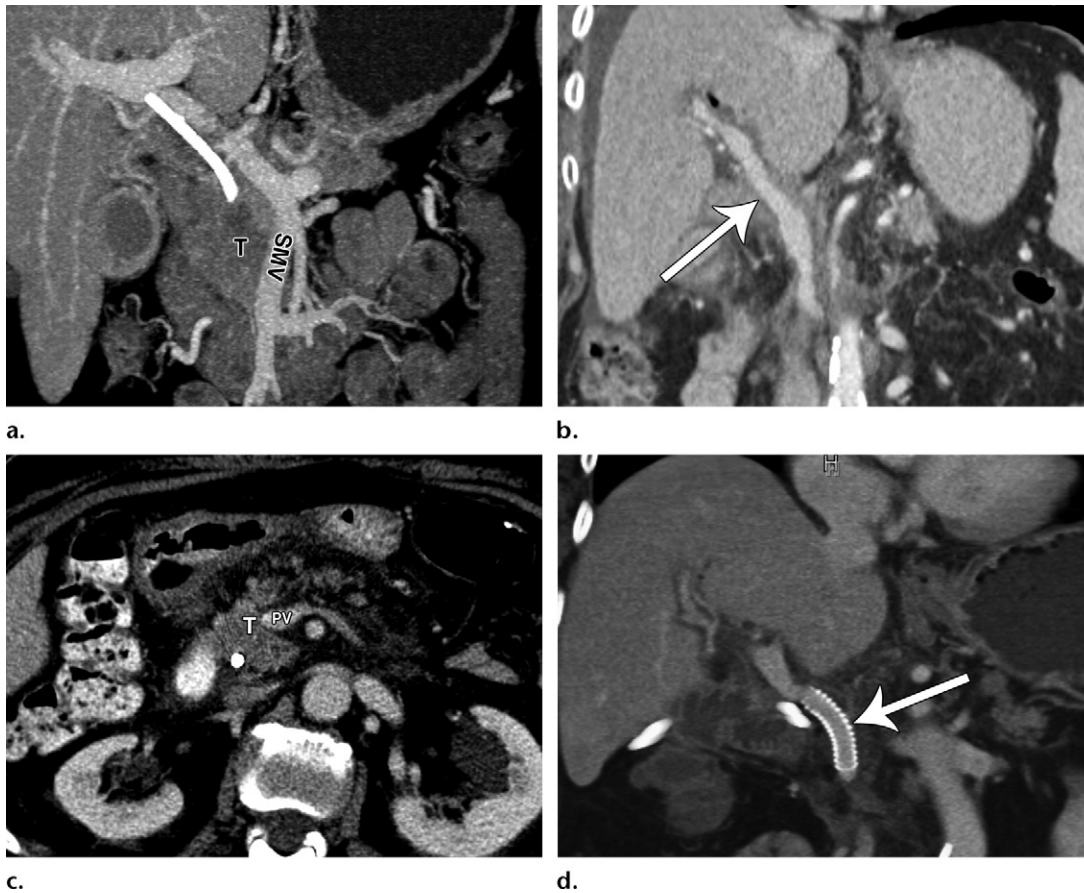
Venous reconstruction in two patients. (a, b) PDAC arising from the head of the pancreas in a 60-year-old woman. (a) Coronal maximum intensity projection CT image shows abutment of the SMV by the pancreatic head tumor (T), without luminal narrowing. (b) Coronal contrast-enhanced CT image obtained 1 month after the surgery shows a patent internal jugular vein graft (arrow) after Whipple surgery with portal vein resection. (c, d) PDAC in an 82-year-old woman. (c) Axial contrast-enhanced CT image shows abutment of the tumor (T) and the portal vein (PV). The patient underwent Whipple surgery with resection and reconstruction of the portal vein with a synthetic polytetrafluoroethylene graft. (d) Postoperative volume-rendered CT image obtained 1 week after surgery shows patency of the graft (arrow).
